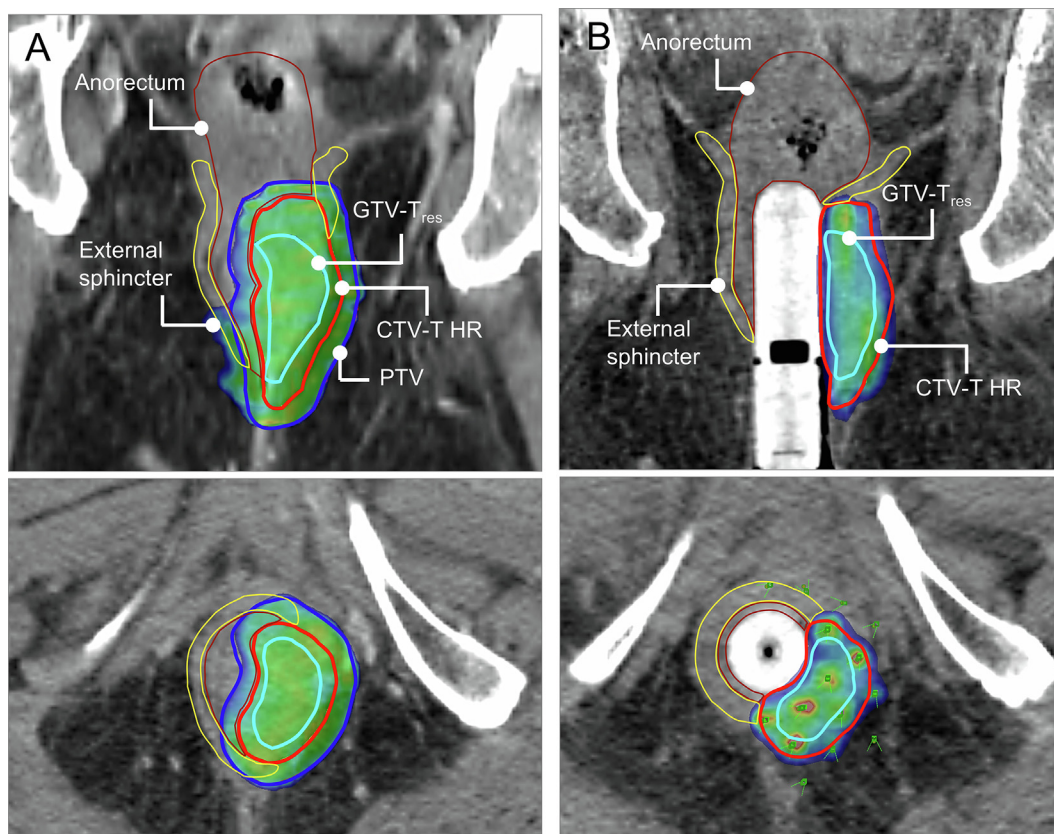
Comparison of volumetric modulated arc therapy (VMAT) with virtual image guided adaptive brachytherapy (IGABT) boost in a patient with a T3 N0 tumor, who underwent planning CT both for VMAT and IGABT. To compare dose distributions, iso-effective prescriptions were selected and D98 was normalized to 95% of prescribed dose both for the PTV_{EBRT} and CTV-T HR_{BT} (Table 3). (A) VMAT plan, optimized to PTV (CTV-T HR + 5 mm). Color wash: 95% to 105% of prescribed dose. (B) Virtual IGABT with a 2 cm anal dilator. Virtual perineal template was projected on CT to place 15 virtual needles in 3 planes at a median depth of 63 mm (range: 37–88 mm). Paris-system plan, specifying the dose at 85% isodose of basal dose-points was used as the starting point and optimized to meet the planning aims. Color-wash: 95% to 200% of prescribed dose. Absence of CTV to PTV margin, sharp dose fall-off and displacement of healthy tissues result in a lower dose to the sphincter and anorectum when compared with VMAT. Simultaneously, superior coverage and dose escalation inside the GTV-T_{res} is achieved. GTV-T_{res} – residual gross tumor volume; CTV-T HR – high risk clinical target volume of the primary tumor.
